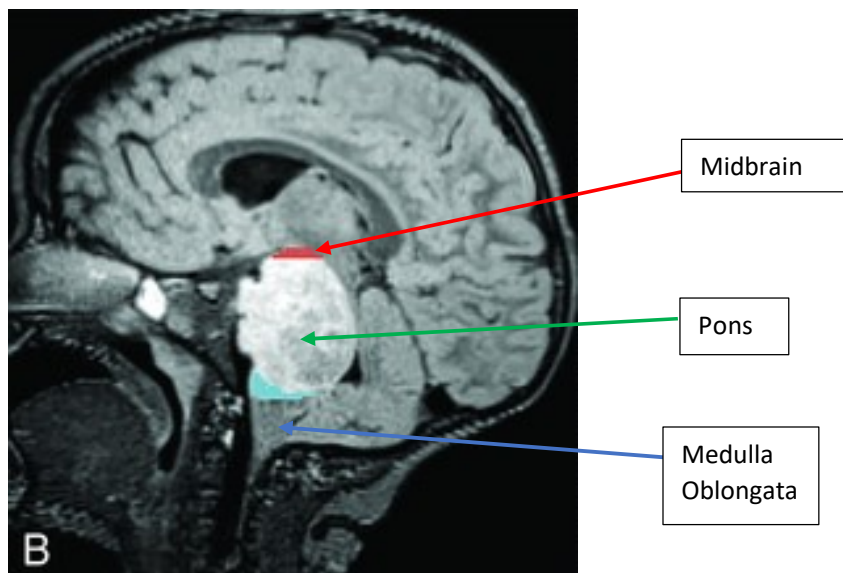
MRI showing the brain of a patient with a DIPG tumour extending into the midbrain and Medulla Oblongata (2).
